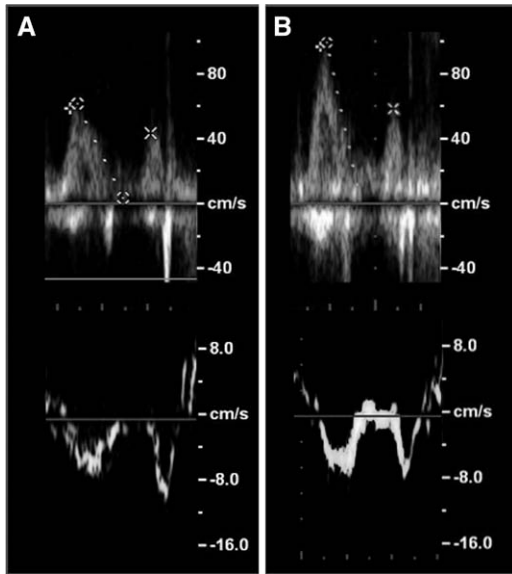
Doppler measurements of the patient in the clinical vignette. Top. The mitral flow pulsed Doppler early and late diastolic flow wave measurements. Bottom. Tissue Doppler measurements at the septal mitral annulus, (A) resting measurements, (B) postexercise measurements.
